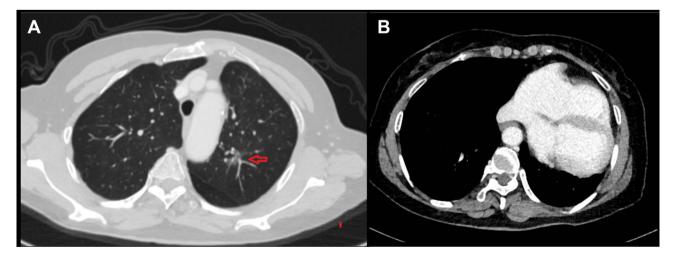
Pulmonary CT images. (A) The pulmonary nodule (red arrows) was located in the S¹⁺² segment of the left upper lung. (B) The cardiac shadow was tilted to the left side of the chest
